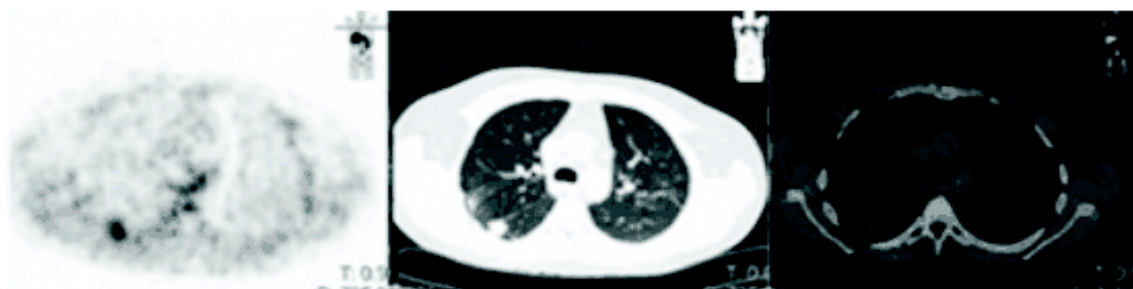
F-18-Choline Mediastinal Lymph nodes: Anterior SUVmax 3.40, Pre-tracheal SUVmax 3.89.
